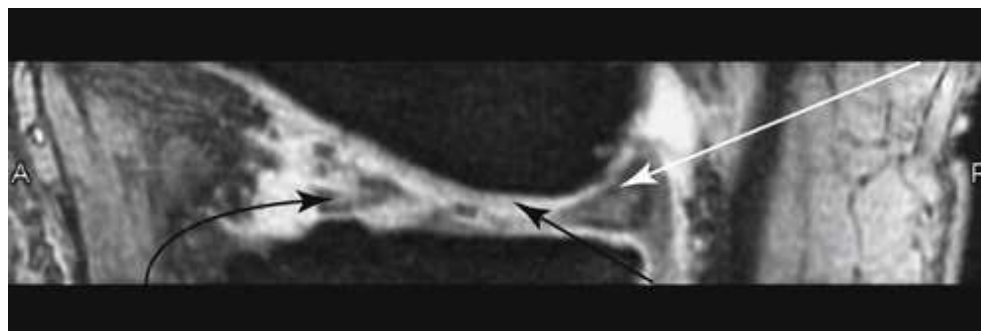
Single slice from three-dimensional acquisition of the knee on a 3-T MRI unit. Data from an entire volume within the imaging coil are obtained concurrently. The data may be reconstructed into thin slices in any plane, such as the sagittal image shown here. This imaging sequence shows hyaline cartilage (*black arrow*) as a rim of fairly high signal intensity overlying the bone. Meniscal fibrocartilage (*white arrow*) has low signal intensity. High signal intensity from joint fluid in a tear (*curved arrow*) within the anterior horn of the meniscus is visualized.
